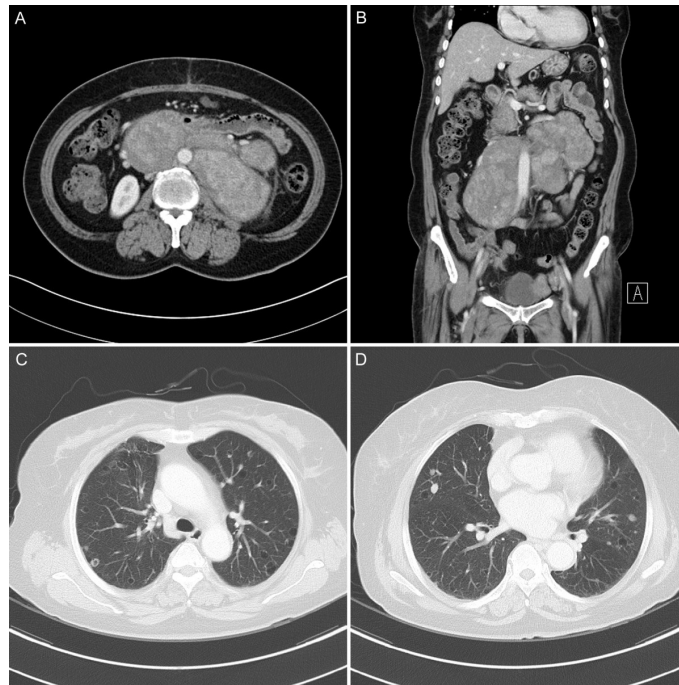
Computerized tomography (CT)
